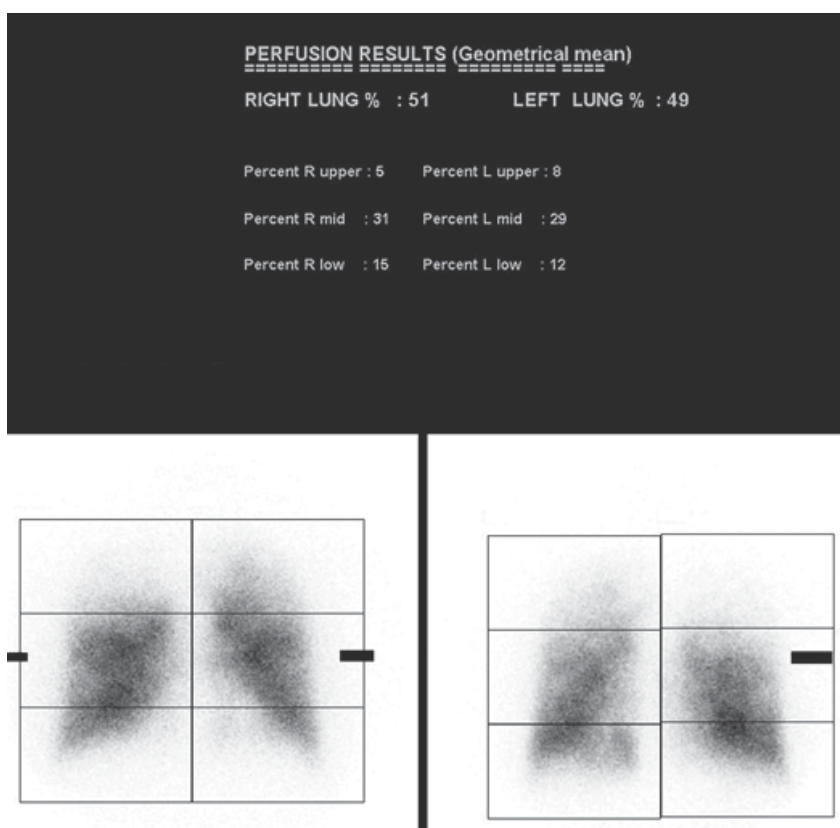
Anterior and posterior images from perfusion scintigram. Three equally sized regions of interest over lungs are shown. Counts in each zone are measured. Geometric means of anterior and posterior images are then used to calculate relative perfusion and ventilation for each zone for each lung. By this method, percentages are obtained for upper, middle, and lower zones of right and left lungs for both perfusion and ventilation. (Win et al., 2006).
